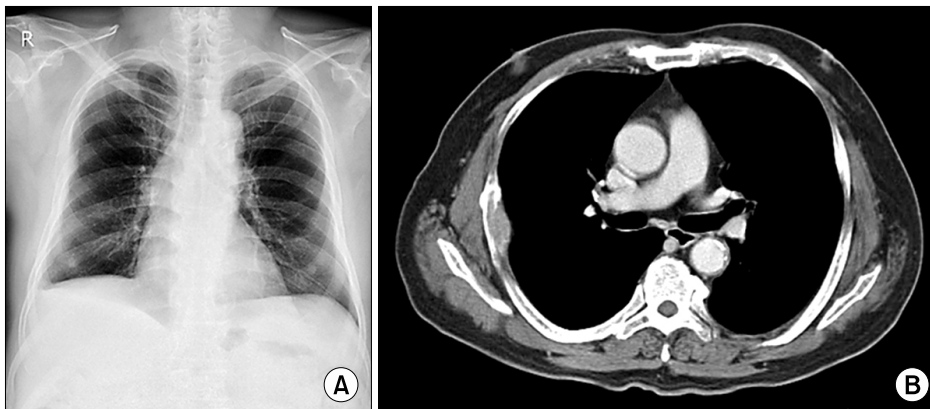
(A) Simple chest X-ray showing pleural thickening around the right 5th rib. (B) Chest computed tomography scan demonstrates rib tumor with osteolytic lesion.
